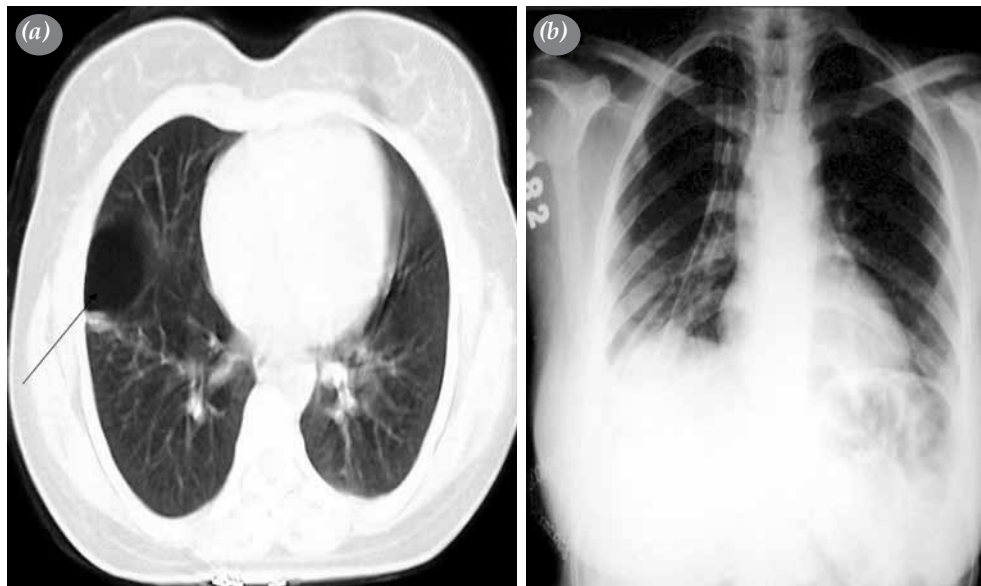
(a) Computed tomographic view of the bulla at the lower lobe of the right hemithorax (arrow). (b) Chest X-ray showing an early postoperative view.
